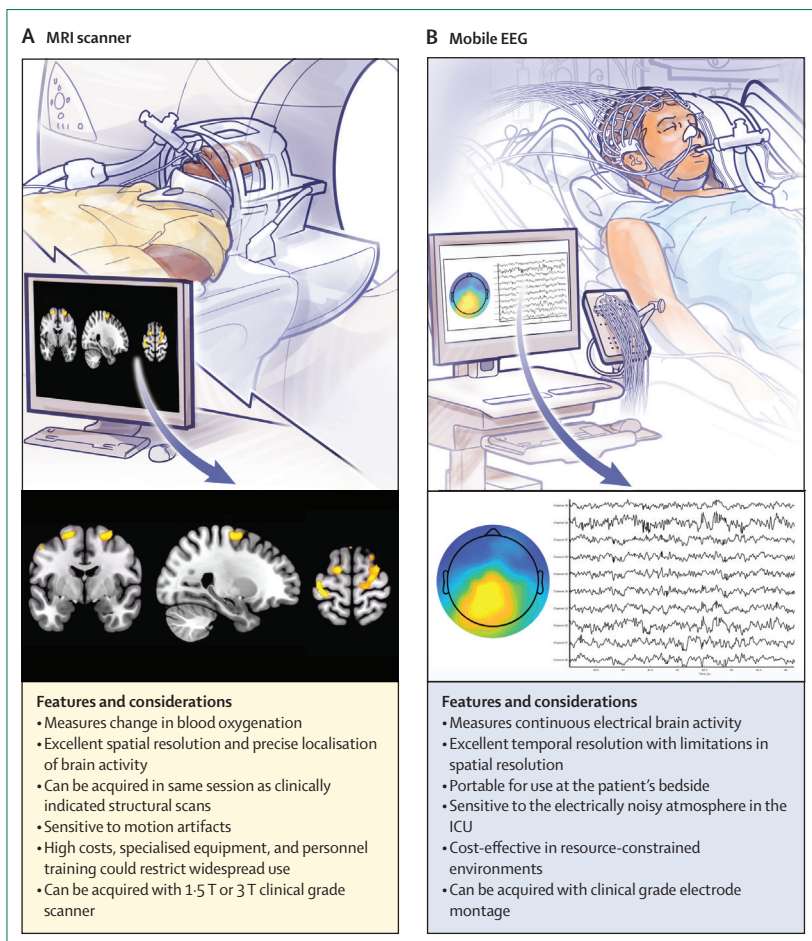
Functional MRI and EEG application in the intensive care unit
